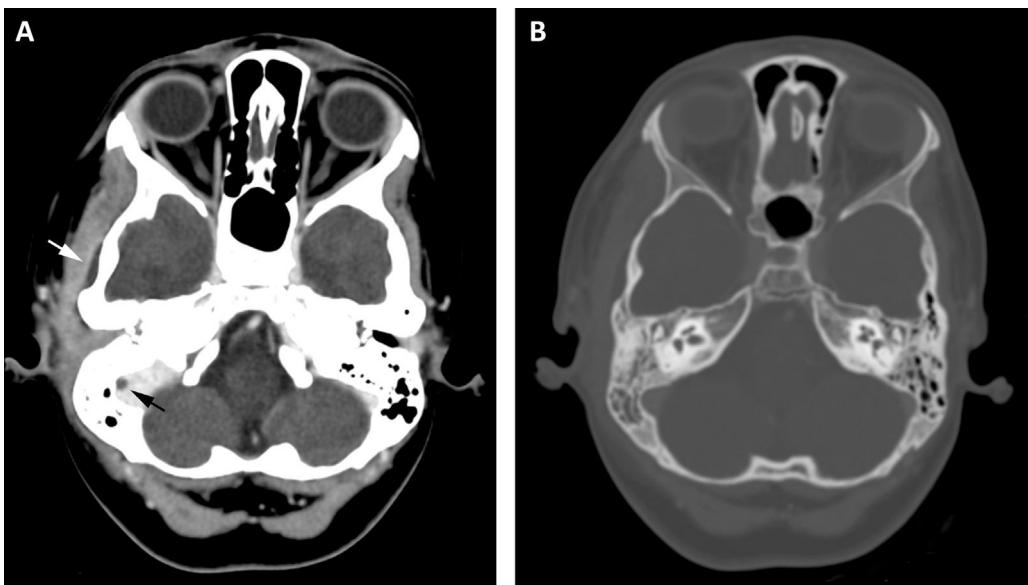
Computed tomography image. (A) Soft tissue window with intravenous contrast: right mastoiditis with temporal subperiosteal abscess measuring 3.5 mm and very small non-occlusive thrombus in sigmoid sinus. Asymmetrical enlargement of soft tissues indicative of reactive myositis in temporalis muscle. (B) Axial CT image, bone window, showing otomastoid fluid buildup.
